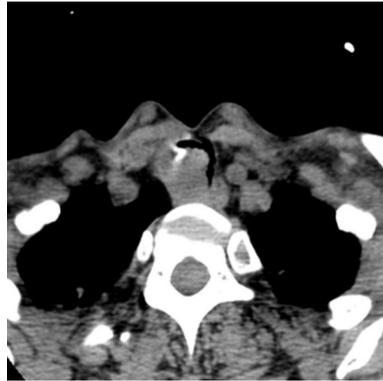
Computed tomography scan showing an inhomogeneous, broad-based lesion arising from the tracheal wall on the right side. Calcification can be seen in the anterior part of the tumor.
